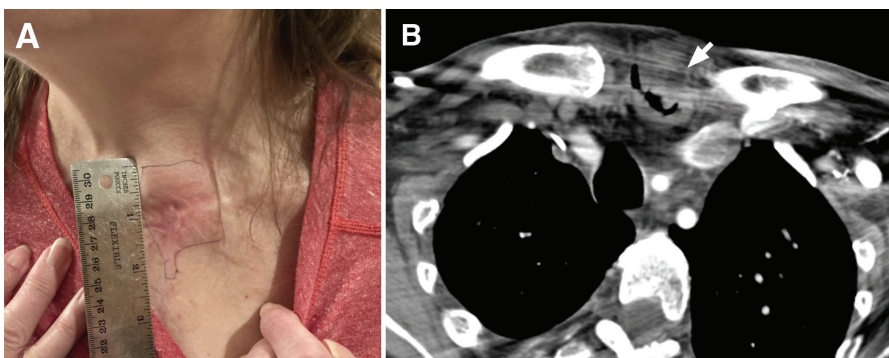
(A) Cellulitis of the neck from colonic diverticulitis in a 55-year-old woman with previous reconstruction of esophageal atresia using a segment of colon. (B) A contrast-enhanced computed tomography scan showed findings typical of diverticulitis, including a fluid-filled false diverticulum (arrow), bowel wall thickening, subcutaneous fat stranding and edema.
